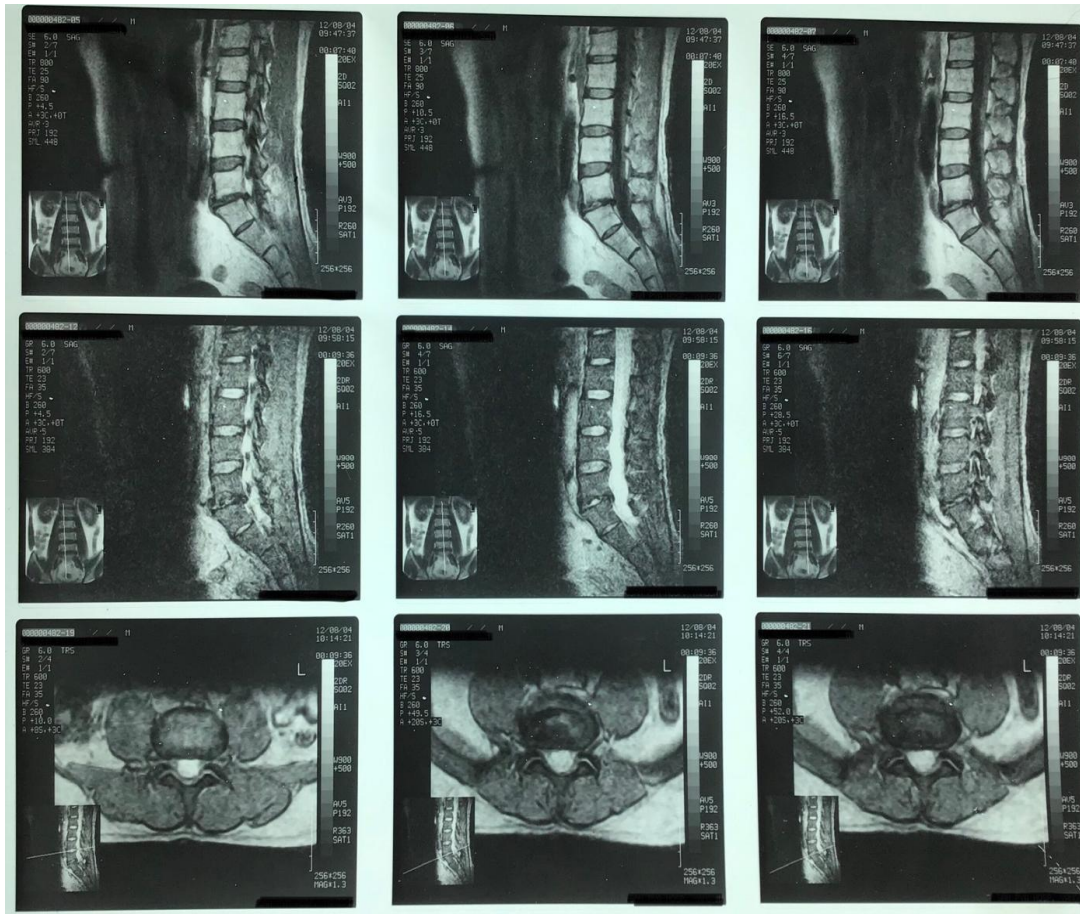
Post-operative 5 years follow-up Lumbar MRI
